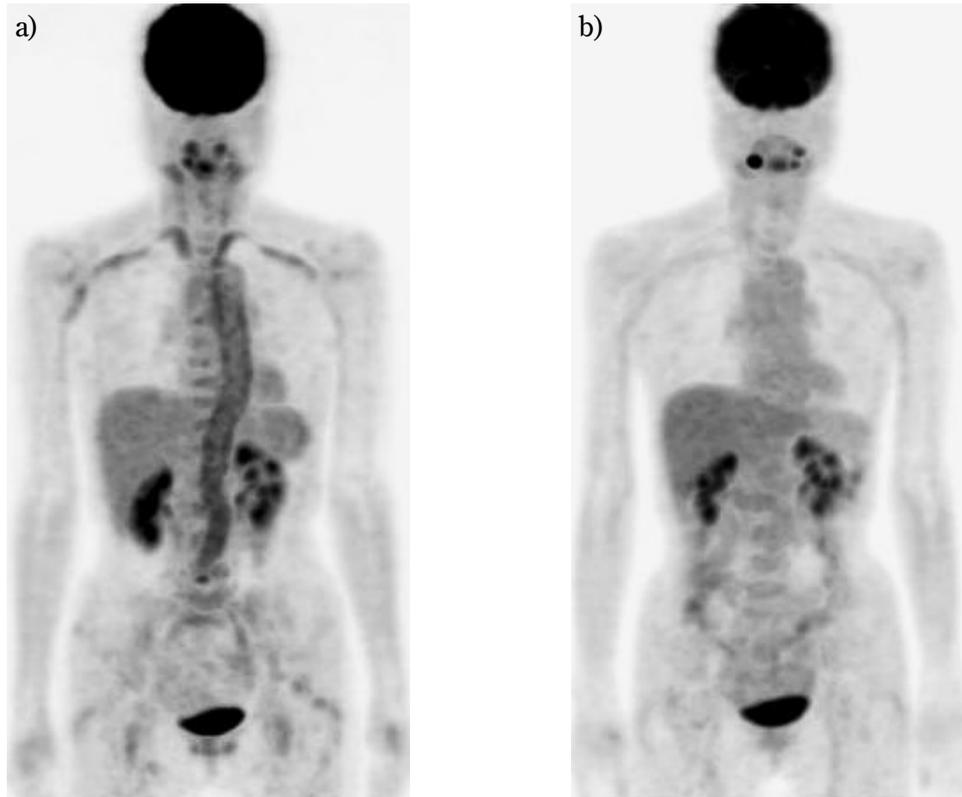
A 72-year-old female. a) FDG-PET image. The diagnosis of vasculitis is confirmed. b) FDG-PET image after steroid therapy. Abnormal uptake in the arterial wall disappeared on repeated FDG-PET.
